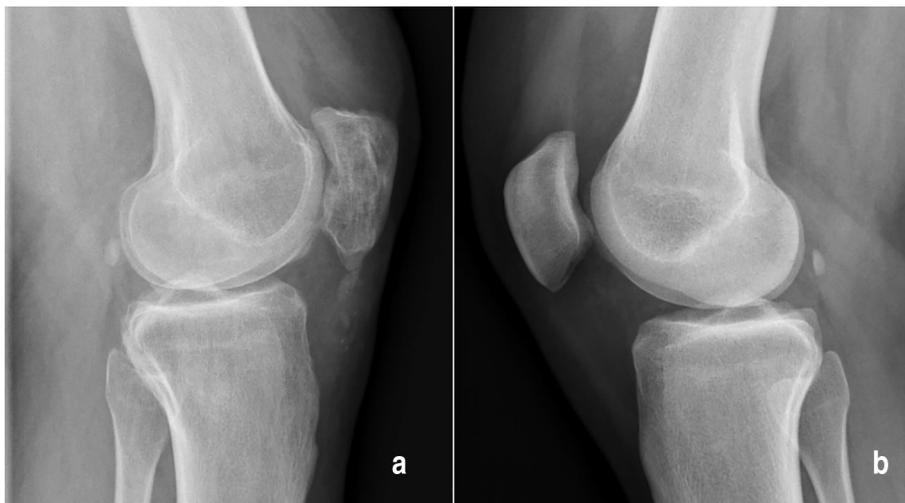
Preoperative radiographs: a. Lateral view of affected knee showing patella infera with CDI = 0.5 (<0.6). b. Lateral view of the contralateral knee with a normal CDI of 1.
